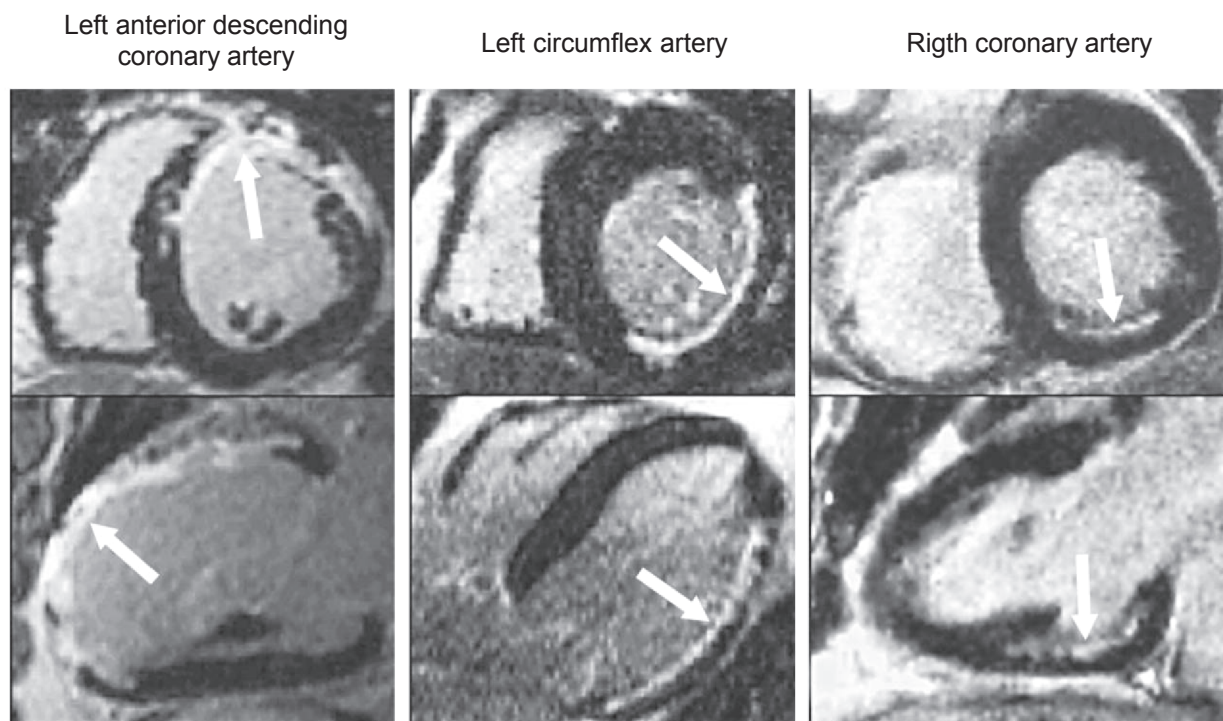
Typical contrast-enhanced images obtained by MRI in a short-axis view (upper panels) and a long-axis view (lower panels) in three patients
